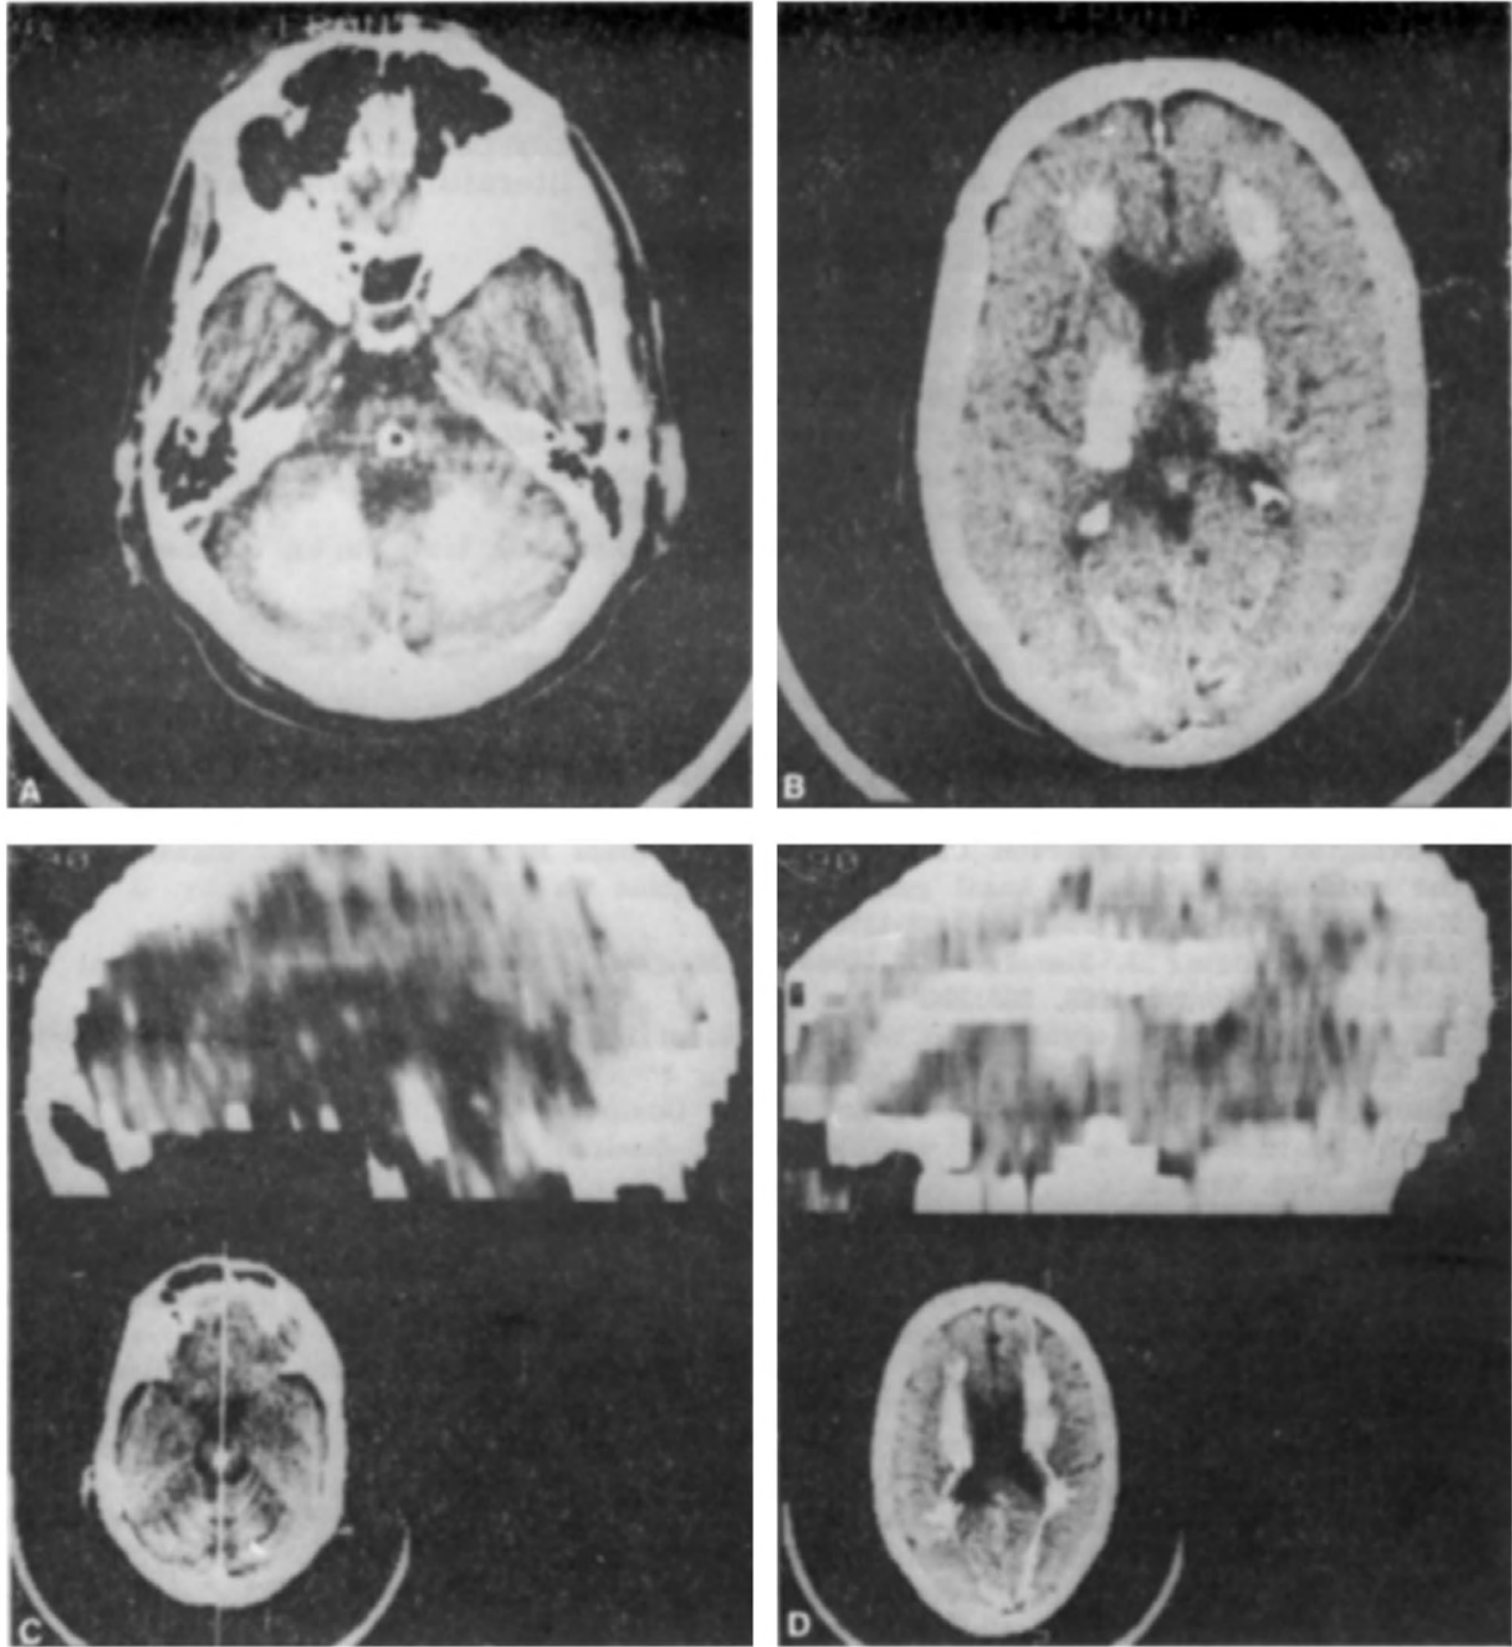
Case JBF. Axial unenhanced computed tomography scans showing calcification of: A. cerebellum and pons; B. frontal and occipital lobes and basal ganglia; C and D. brainstem and periventricular region in transverse reconstruction.
